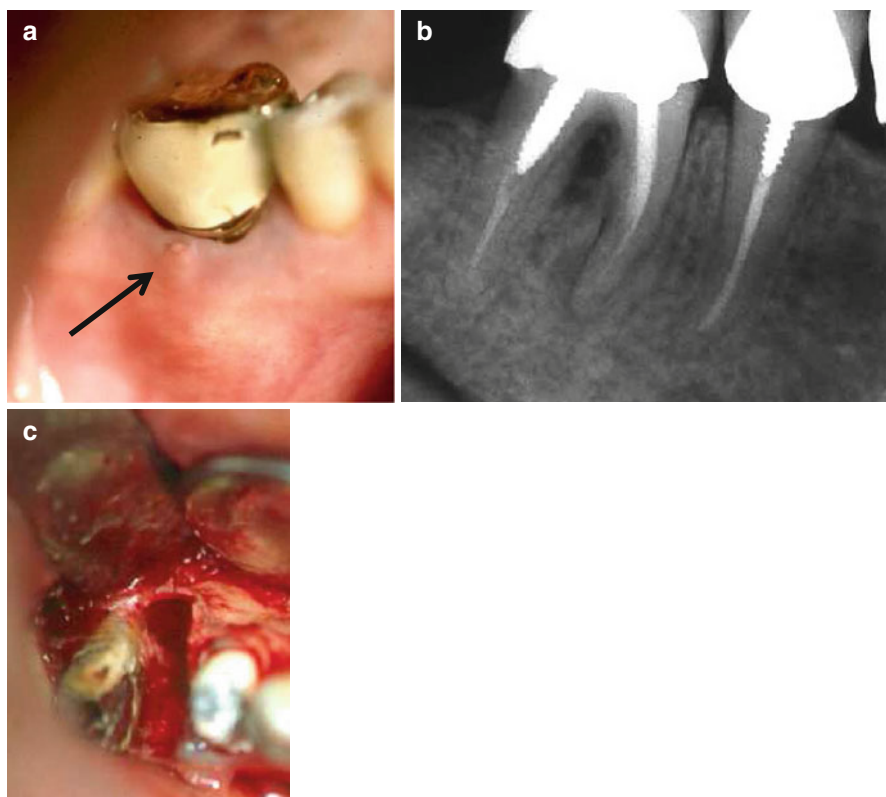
Treatment option on a mandibular molar. (a) “pathognomonic combination” in a mandibular first molar. 9 mm probing in midbuccal area, and a cervically located sinus tract (*arrow*). (b) Periapical radiograph reveals combined bifurcation and “halo” radiolucency around the mesial root. (c) Following crown removal, the mesial root was amputated
